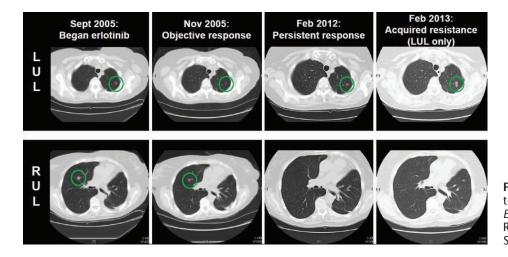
Radiographic response to erlotinib in patient with *EGFR* S768I mutation (–40% by Response Evaluation Criteria in Solid Tumors v1.1).
